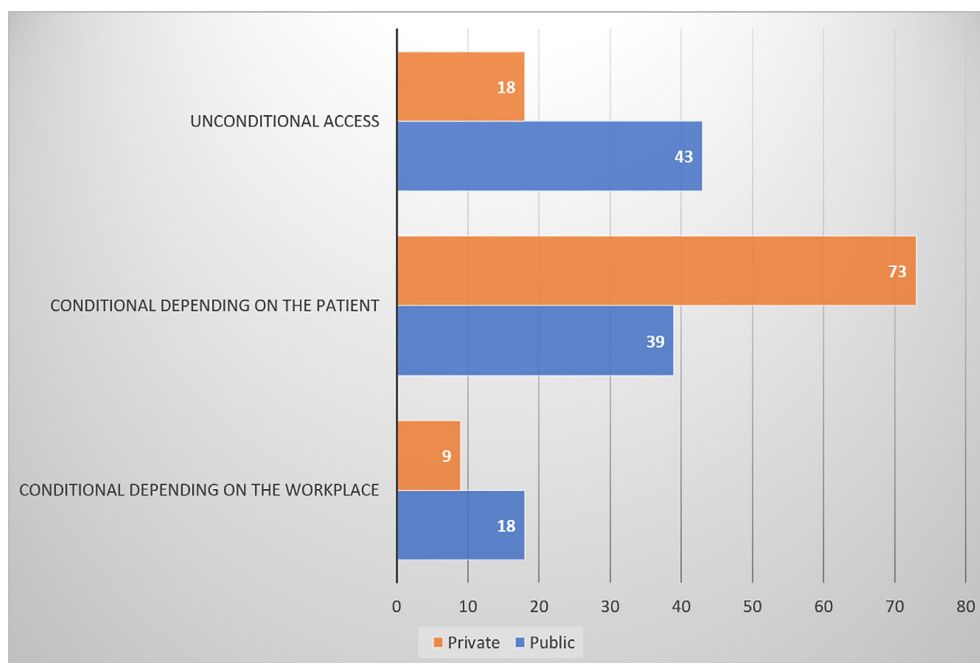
Restrictions on access of public hospital versus private practice sonographers to protective equipment. Total number of sonographers in private practice = 228, total number of sonographers in public hospitals = 76
